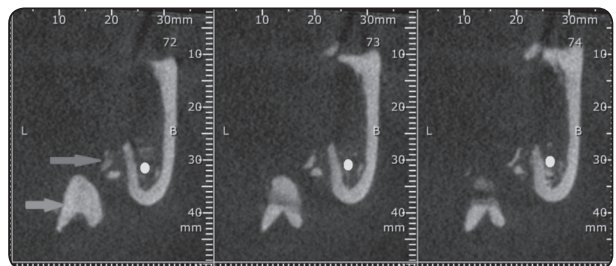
Cone beam CT showing: The displaced wisdom roots in submandibular space (blue arrow) & fracture of the lingual plate (red arrow).
